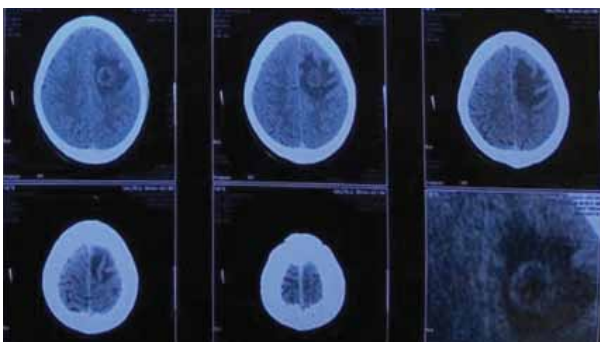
CT-scan of Brain with contrast- Single rim enhancing hypodense lesion in the left fronto-parietal region with peri-lesional edema.
